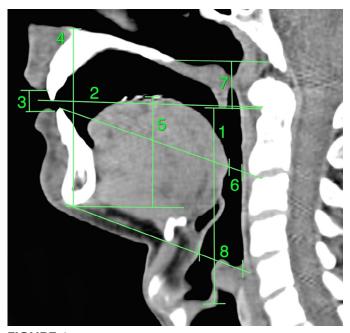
Distances (mm) measured in computerized tomography (CT) midsagittal images: (1) vertical length of the vocal tract, (2) horizontal length of the vocal tract, (3) lip opening, (4) jaw opening, (5) tongue dorsum height, (6) oropharynx width, (7) velum elevation, and (8) hypopharynx width.
